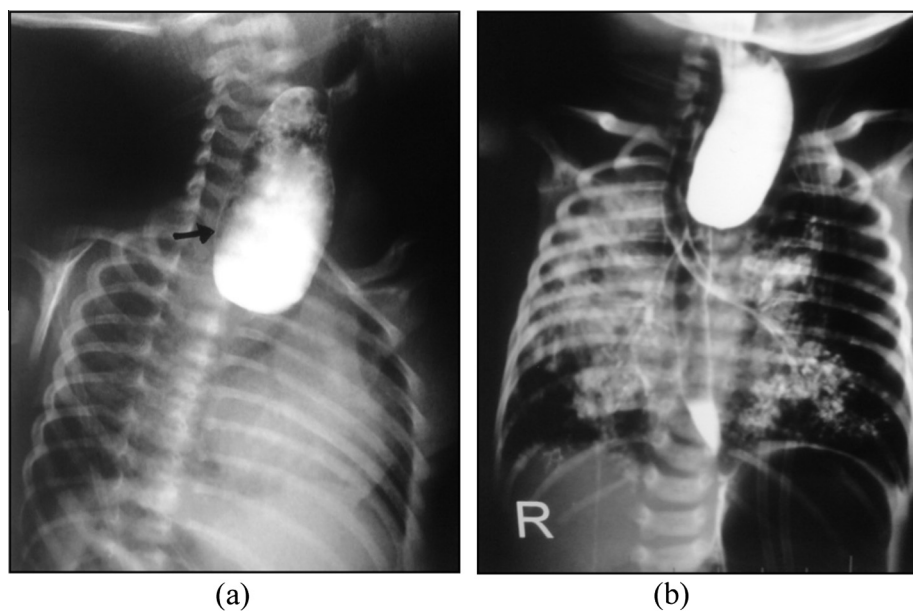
Frontal radiography with contrast study for TEF patient shows proximal esophageal pouch arrow in (a) and aspiration of contrast within trachea and bronchial tree in (b).
